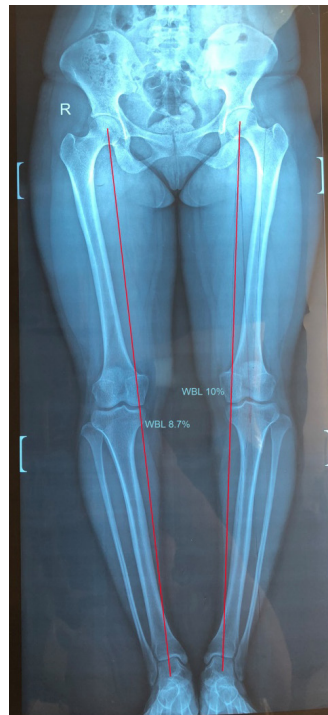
X-ray images showing the pre- and postoperative weight-bearing line.
